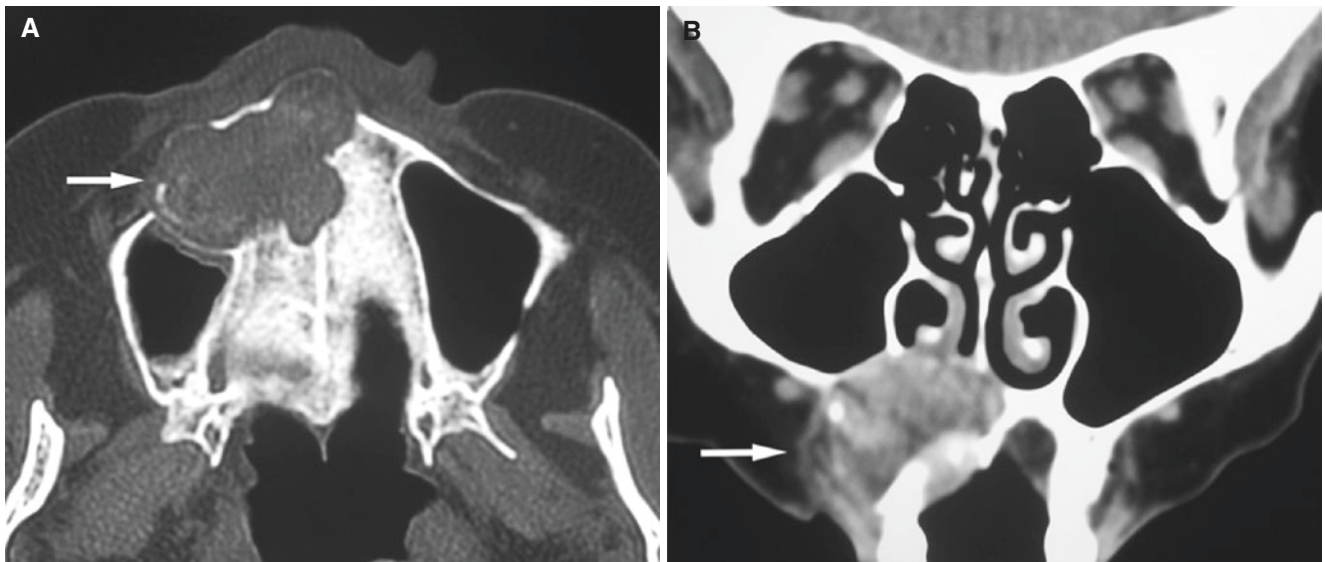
Ameloblastoma, solid/multicystic, maxilla; 80-year-old female with painless swelling in the vestibulum and palate. (A) Axial CT image shows scalloped expansive process with destruction of palate
